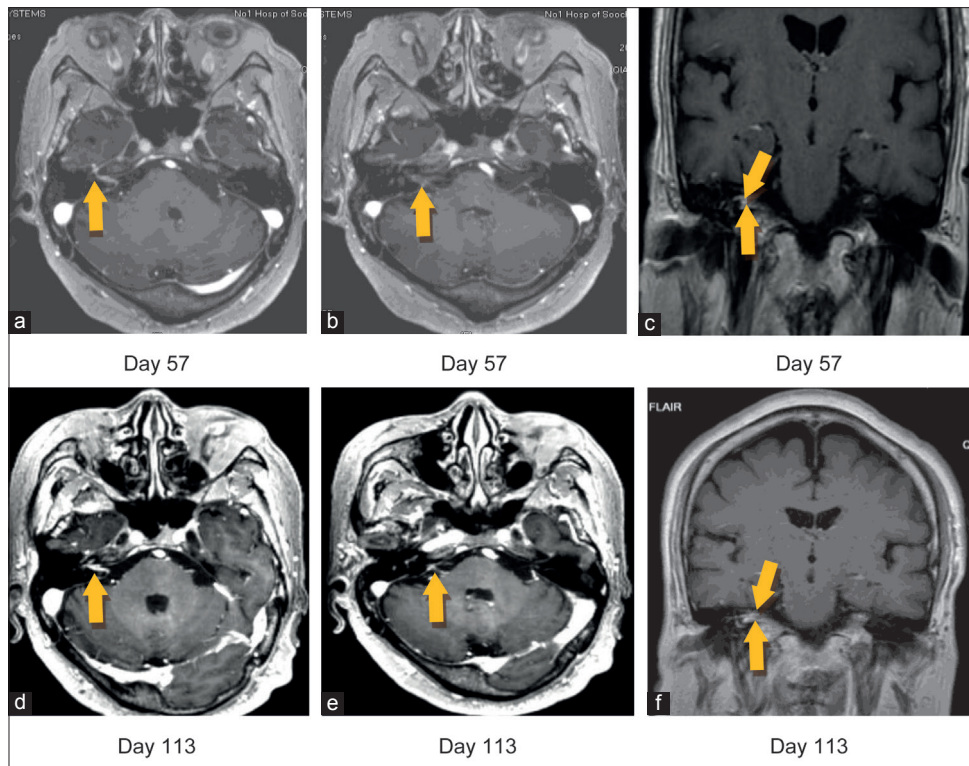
Gadolinium (Gd)-contrast enhanced magnetic resonance imaging (MRI) of cerebrium demonstrates the contrast-enhanced axial T1-weighted image shows enhancement in the facial nerve (arrow) and vestibulocochlear nerve (arrow) on day 57 (a,b, and c). Gadolinium (Gd)-contrast enhanced MRI of cerebrium on day 113 shows the contrast-enhanced axial T1-weighted changes in the facial nerve (arrow) and vestibulocochlear nerve (arrow) had not resolved (d,e, and f).
